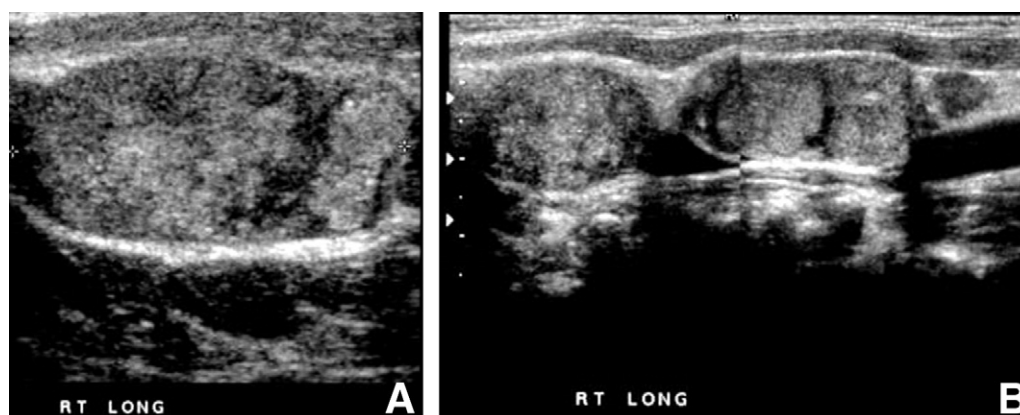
An 11-year-old patient with multiple right sided neck masses. Longitudinal views from a thyroid ultrasound confirm multifocal solid masses in the right lobe of the gland (A) and cervical lymphadenopathy (B) in this patient with extensive metastatic papillary thyroid carcinoma.
